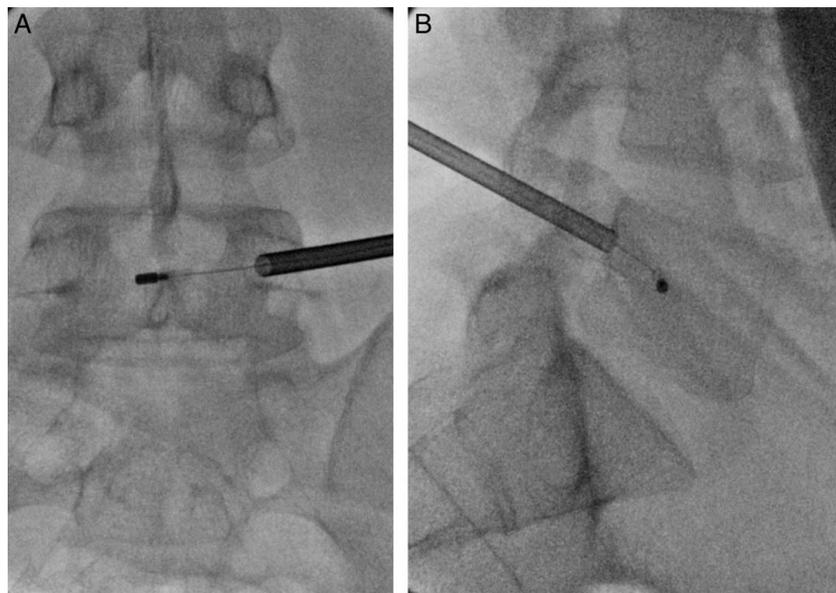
A, AP x-ray demonstrating final midline position of the electrode at L5. B, Lateral x-ray with final position of the electrode between 30% and 50% from the posterior vertebral body and 50% from the superior and inferior endplates.
